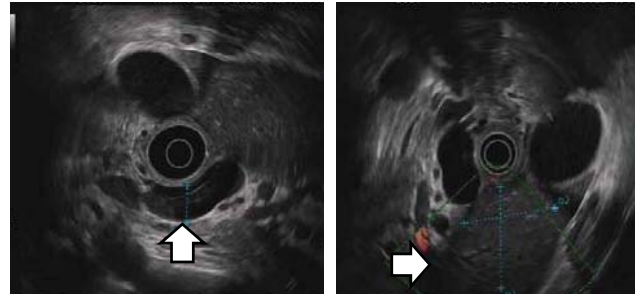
Endoscopy ultra sonography (EUS) showing dilatation common bile duct (CBD) and head pancreas mass
